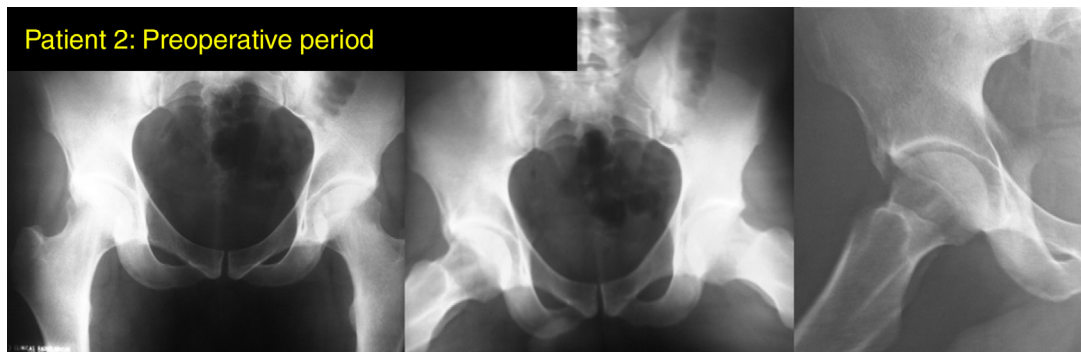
Hip radiographs of patient 2 on Dunn bilateral AP and lateral views. The prominence of AIIS in the right hip may be unnoticed in these views, but is evident in the iliac oblique view.
